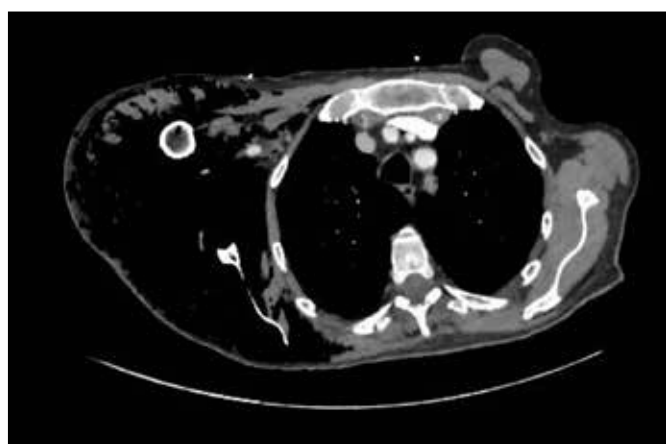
Transverse section of CT Thorax. Warrington Hospital.
